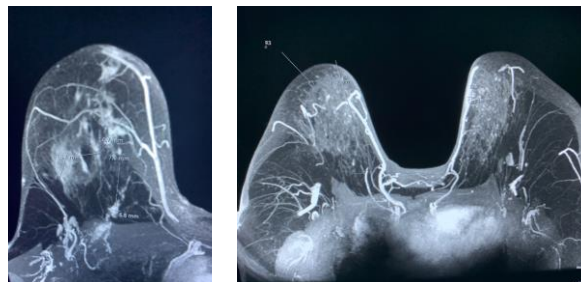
MRI identifying internal mammary artery perforator dominant blood flow
